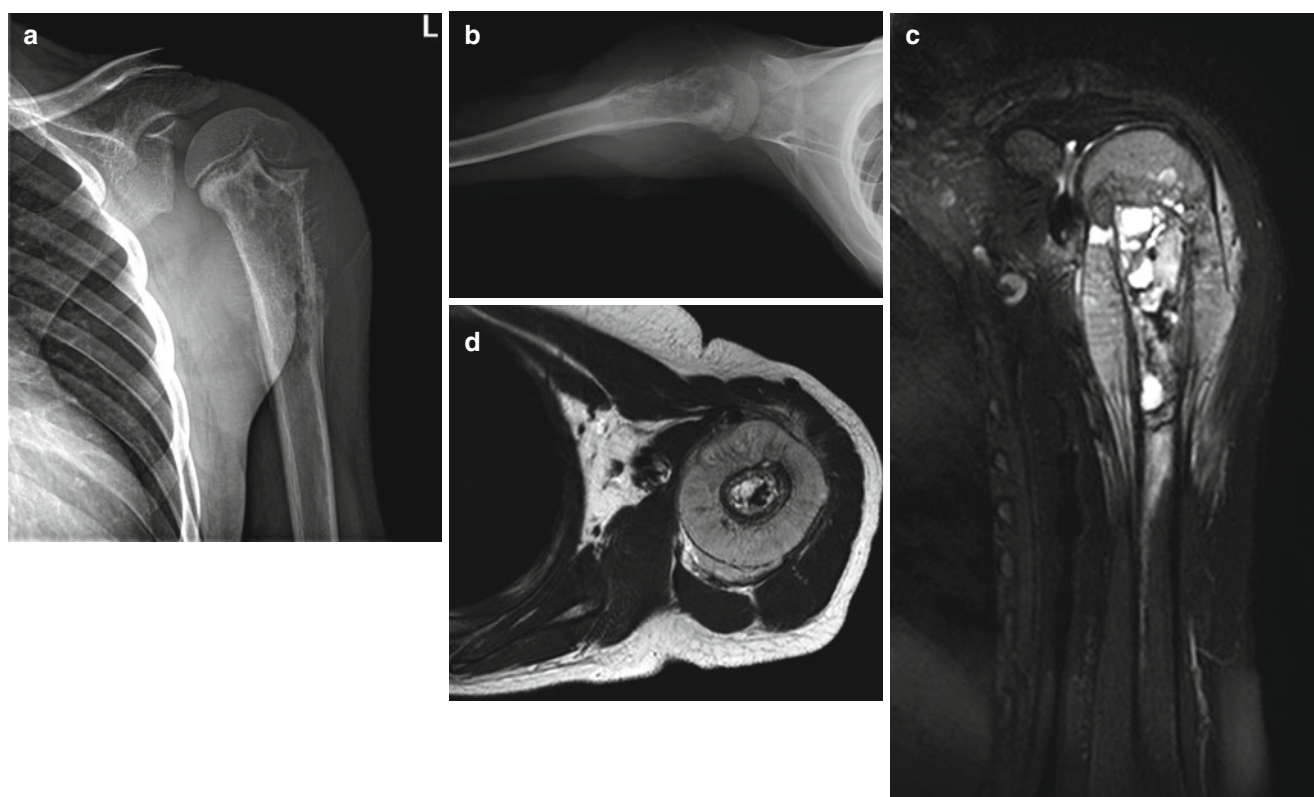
Osteosarcoma in a 10-year-old boy.* (a, b) Left humerus radiographs show ill-defined osteolytic lesion in the left humerus meta-diaphysis with relative lack of blastic activity in this case. There is malignant periosteal reaction of a “hair-on-end” appearance and a “Codman triangle.” (c, d) T2 SPAIR coronal (c) and axial (d) images
